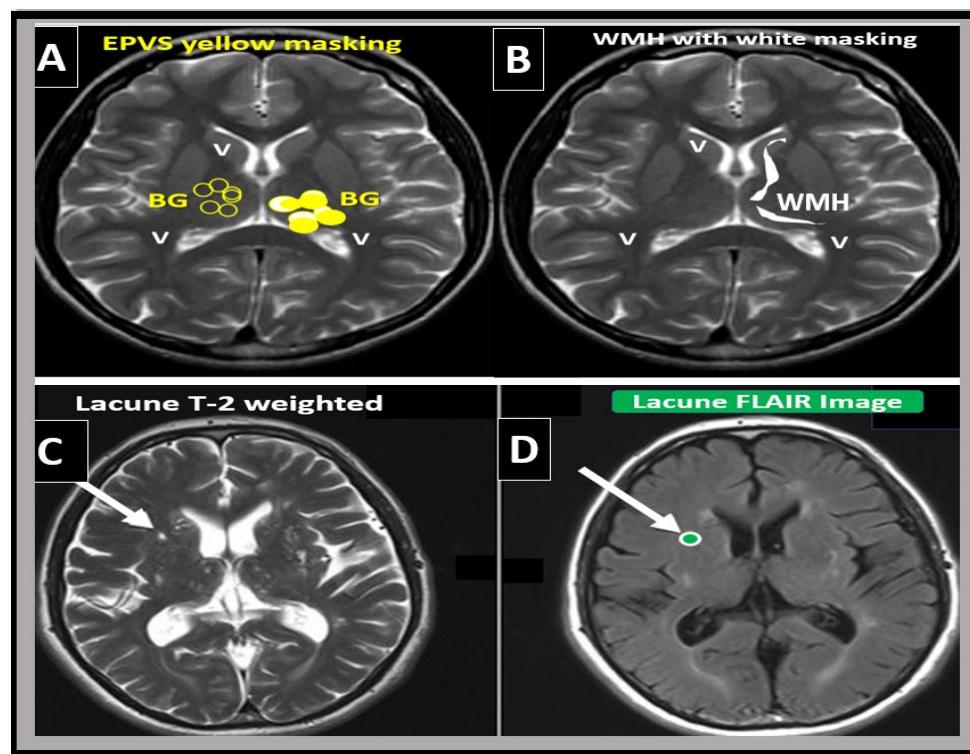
Magnetic resonance imaging (MRI) comparison of enlarged perivascular spaces (EPVS), white matter hyperintensities (WMH), and lacunes. (A) depicts EPVS localized to the basal ganglia (symmetrical) with yellow color masking of EPVS (EPVS localized to centrum semiovale not shown). (B) depicts WMH localized to the periventricular regions (deep white matter WMH not shown). (C) depicts a T-2 weighted lacune (arrow). (D) depicts a FLAIR image with cyan color masking. Note the encircling white line to suggest hyperintensity FLAIR. *V* = ventricle.
